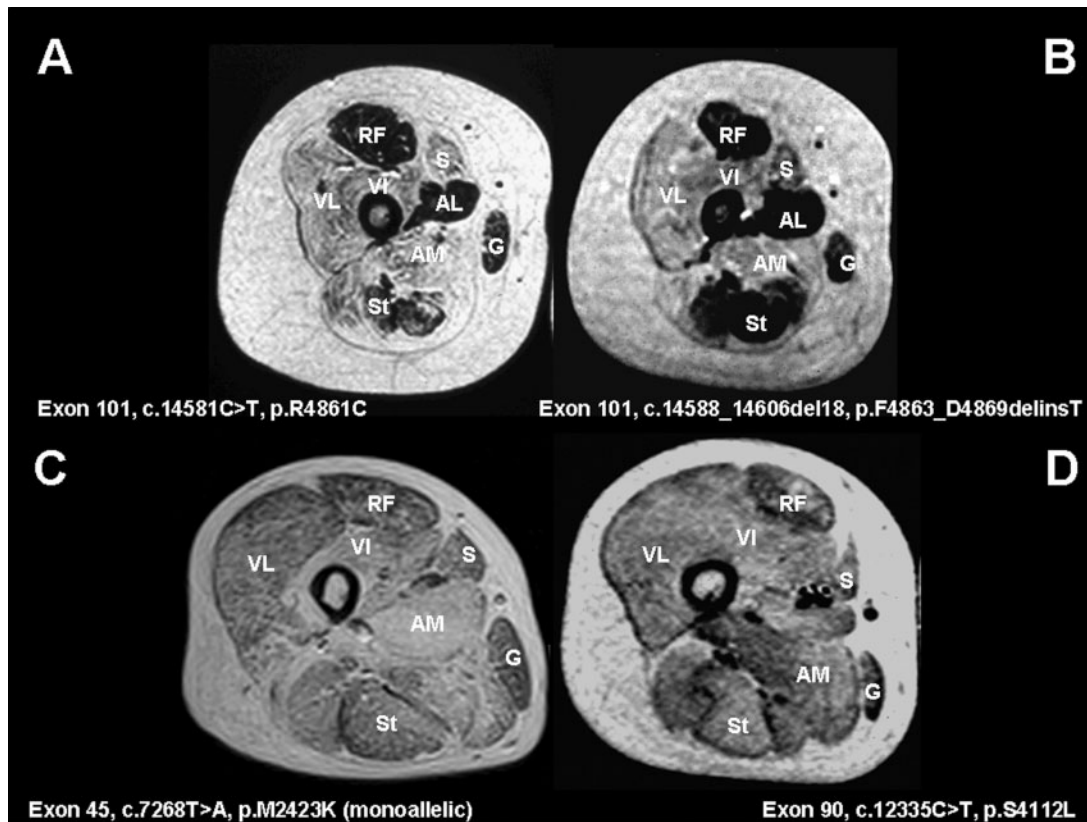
Muscle MRI in *RYR1*-related congenital myopathies. T1-weighted MR images, transverse sections through the proximal thigh in an 11-year old boy (A) (case 6) and a 12-year old girl (B) (case 10) with central core disease (CCD), a 41-year old male with multi-minicore disease (MmD) and external ophthalmoplegia (C) (case 25) and a 9-year old girl with centronuclear myopathy (CNM) and external ophthalmoplegia (D) (case 16). In patients with typical CCD due to heterozygous dominant mutations affecting C-terminal exons 100–102 (A–B), there is a consistent pattern of selective muscle involvement characterized by marked increase in abnormal signal within vasti (VL, VI), sartorius (S) and adductor magnus (AM) and relative sparing of rectus femoris (RF), adductor longus (AL), gracilis (G) and semitendinosus (St). In patients with MmD and external ophthalmoplegia due to recessive *RYR1* mutations (C) and CNM and external ophthalmoplegia due to a heterozygous dominant *RYR1* mutation (D), there is more diffuse involvement (corresponding to more generalized weakness and wasting on clinical examination) but persistent relative sparing of the rectus femoris (RF) compared to the vastus intermedius (VI) and the gracilis (G) compared to the sartorius (S).
